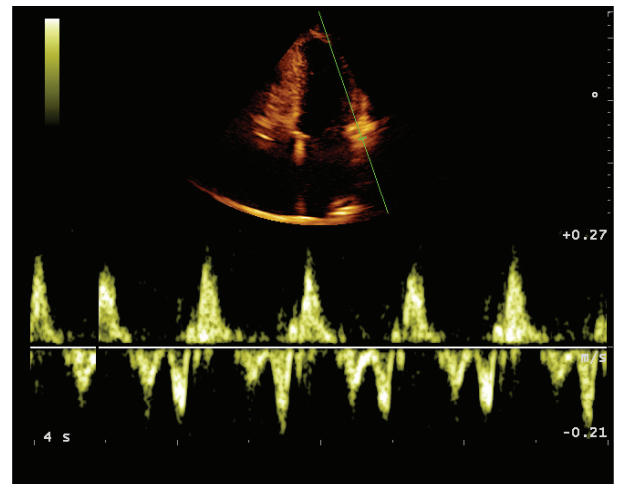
2DTT echocardiogram shows TDI pattern with high-velocity mid-systolic spike named Pickelhaube Sign, like spiked German military helmet
